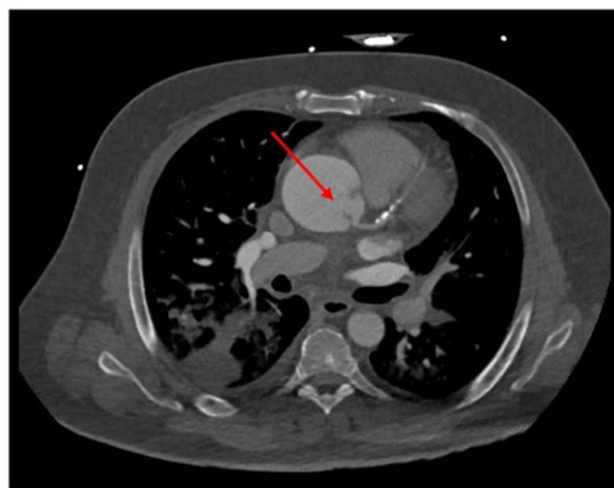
Chest CT scan showing a dilated ascending aorta (52 mm) with two intima flaps and mural hematoma. One intima flap close to the Left Main artery (red arrow).
